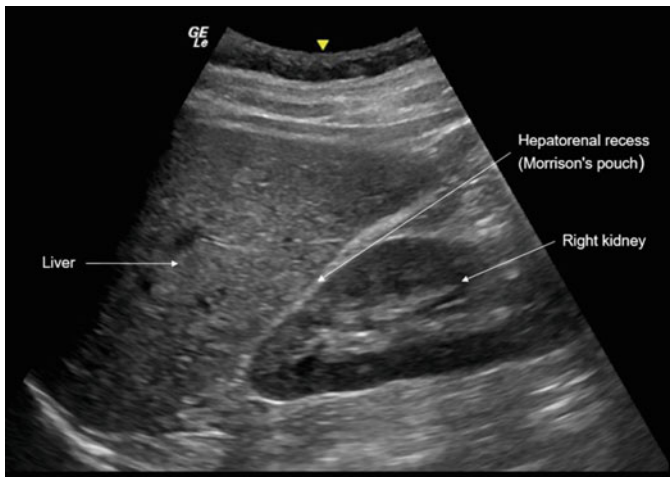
The hepatorenal recess is a potential space between the kidney and liver. It is important to visualize this space on ultrasound because it is one of the first places where fluid, such as ascites or blood, accumulates
